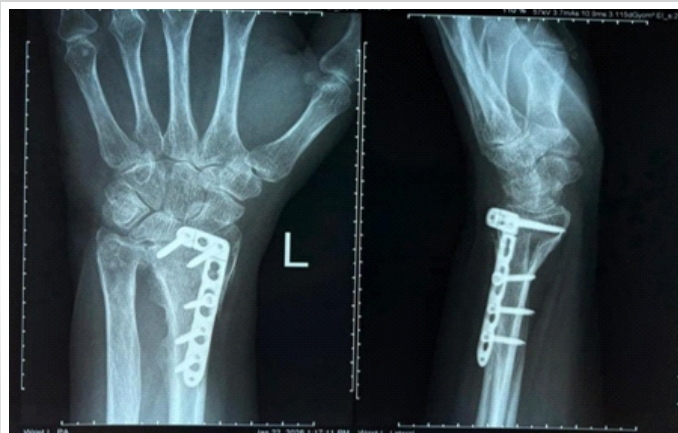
Pre-operative radiograph showing a united distal radius fracture with dorsal plate and screw fixation with distal plate prominence.
